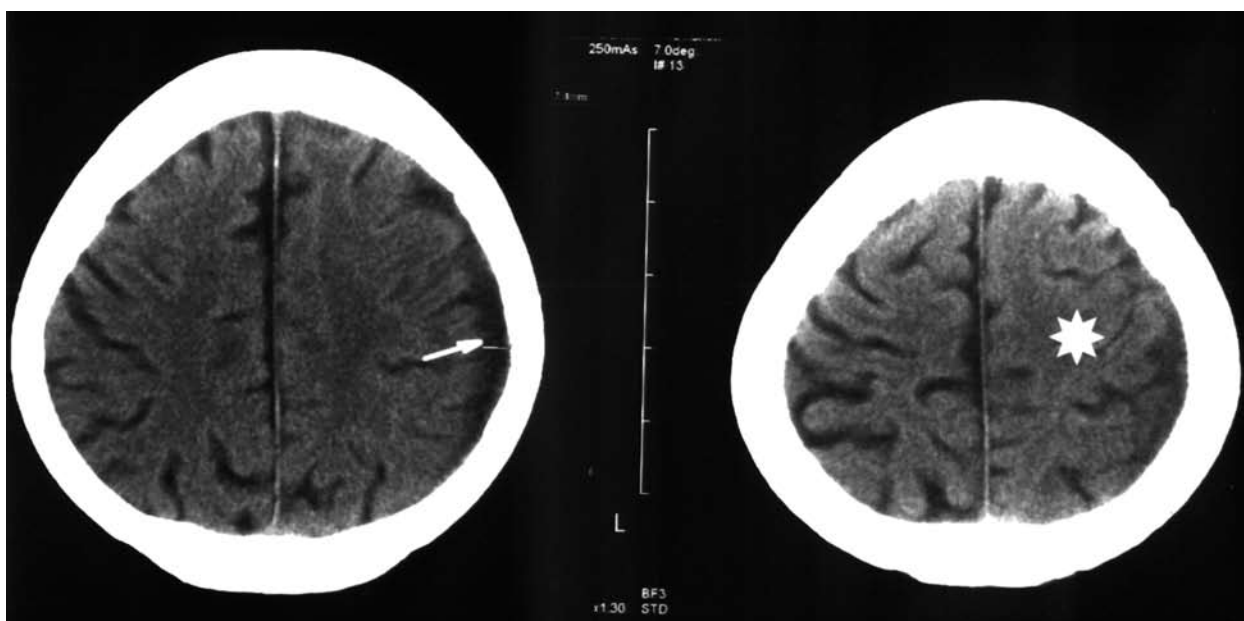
First follow up CT scan shows 50% resolution of the left-sided chronic subdural hematoma (white arrow) with lowering of swollen lobe and better presented subarachnoid space (white star).
